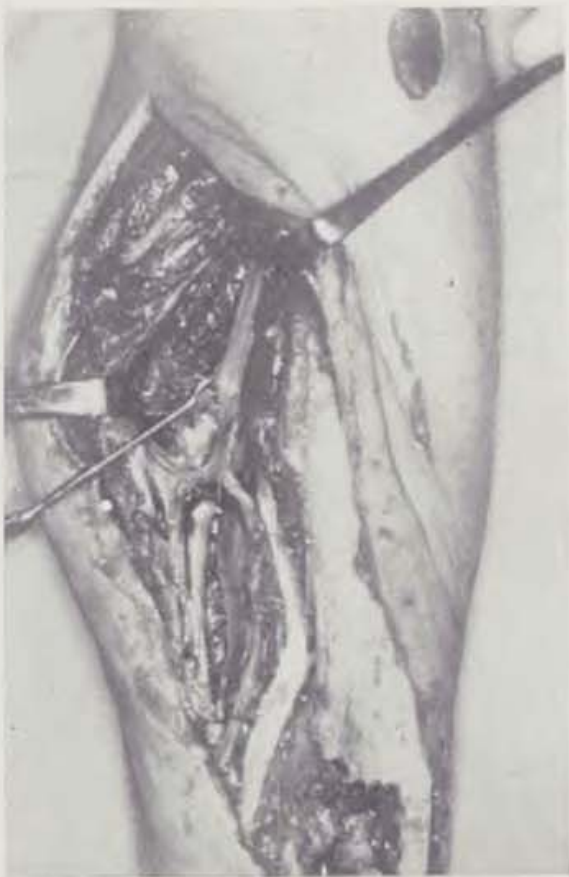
Preoperative view shows skin and bone defect. — Fig. 1b X-ray shows fractures and tibial bone defect
